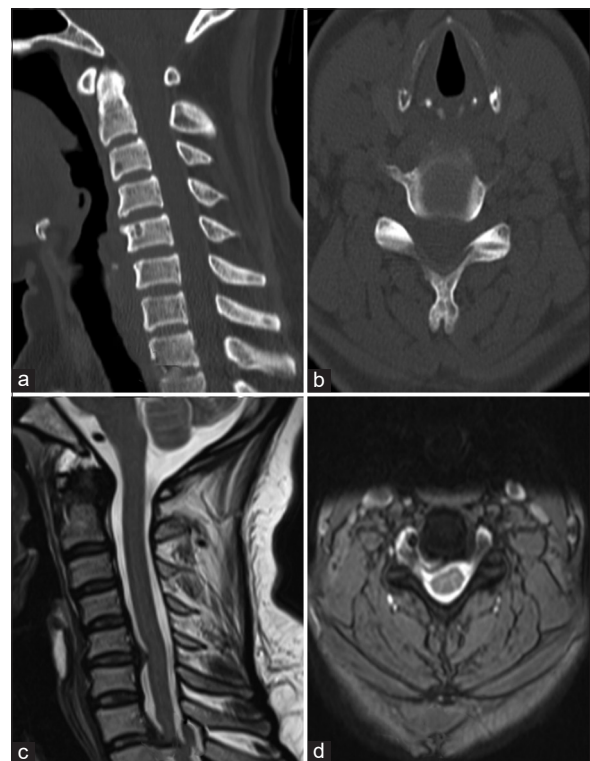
Preoperative computed tomography scan – sagittal view (a), axial view (b), preoperative magnetic resonance imaging sagittal view (c), axial view (d)
